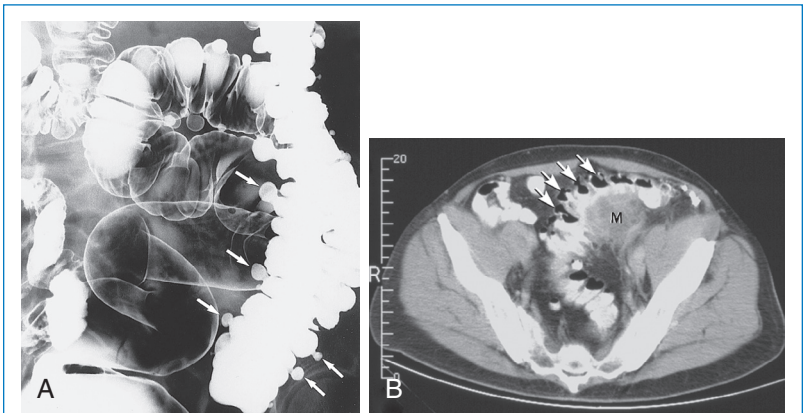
A, Diverticulosis of the colon is seen on this oblique view of the sigmoid colon during a double-contrast barium enema showing multiple outpouchings (arrows) that represent diverticula. B, Diverticula also can be seen in a computed tomography (CT) scan as outpouchings (arrows), but a developing focal inflammatory mass (M) also is compatible with a developing abscess. (From Mettler F. *Essentials of radiology*. 2nd ed. Philadelphia: Saunders, 2004, Fig. 6-73.)
